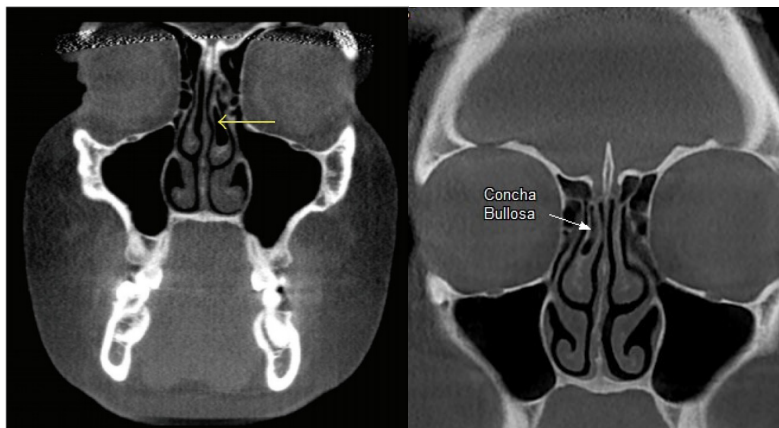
(Left) Concha bullosa on frontal view CBCT; (Right) Unilateral concha bullosa.
